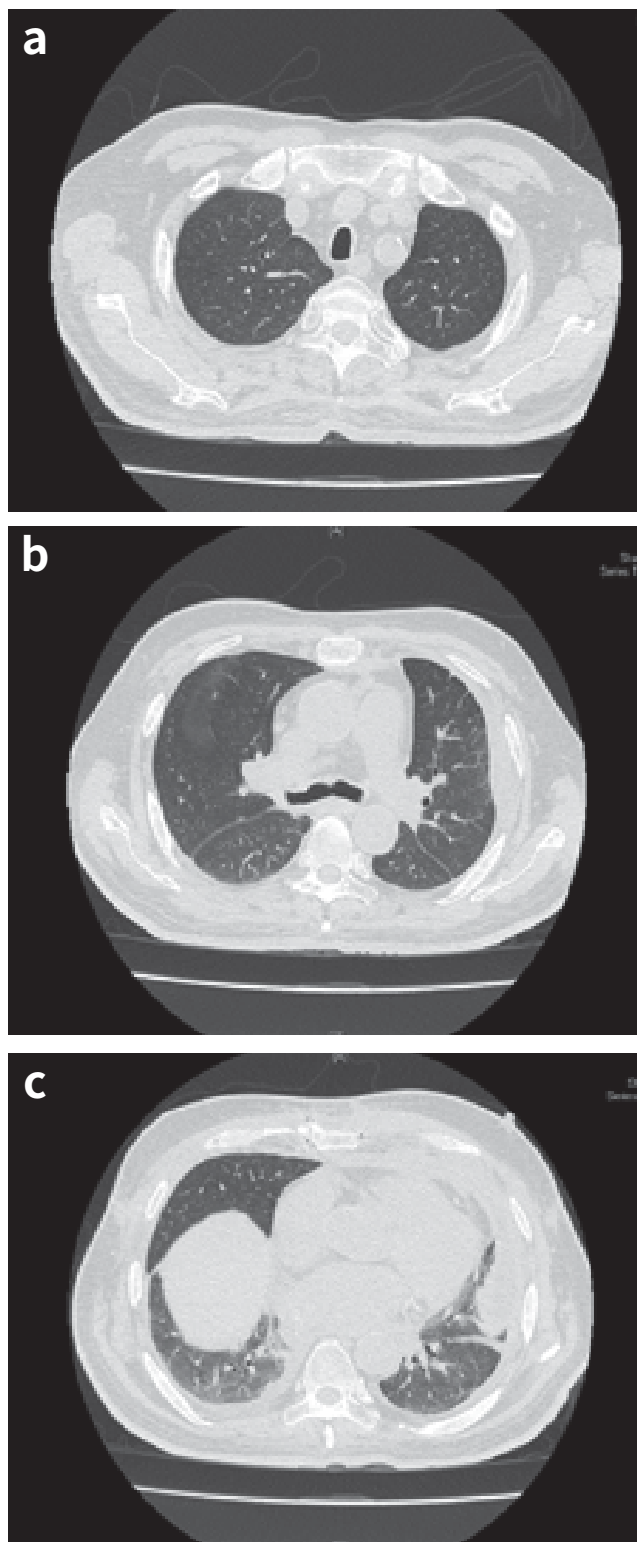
(2016/01/28) and 2b(2017/04/11): HRCT findings
